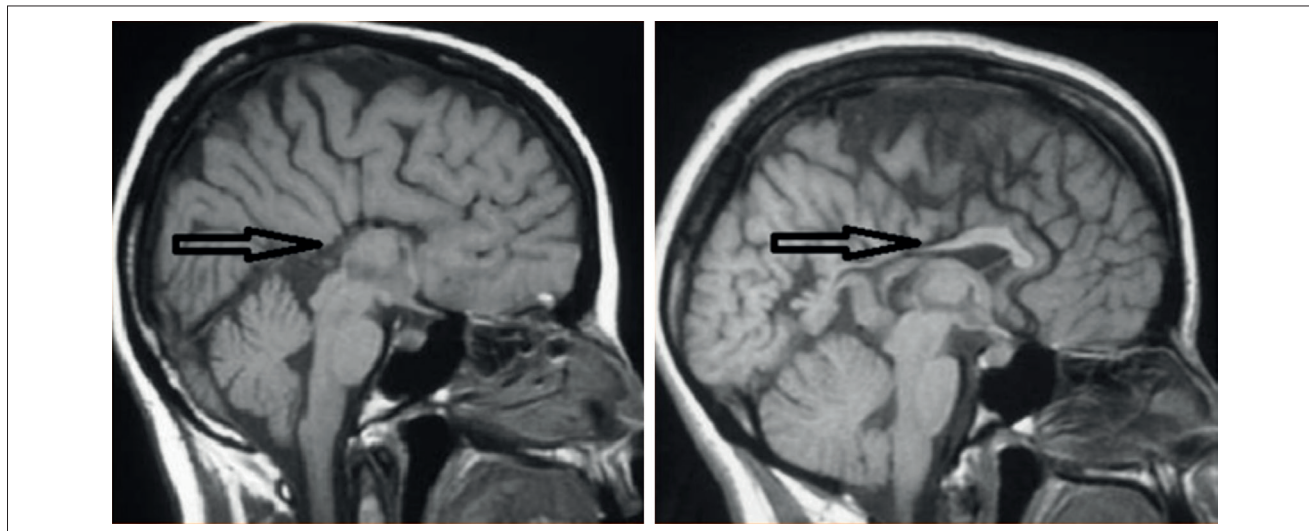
MRI showing complete (right) and partial agenesis of the corpus callosum (left).
